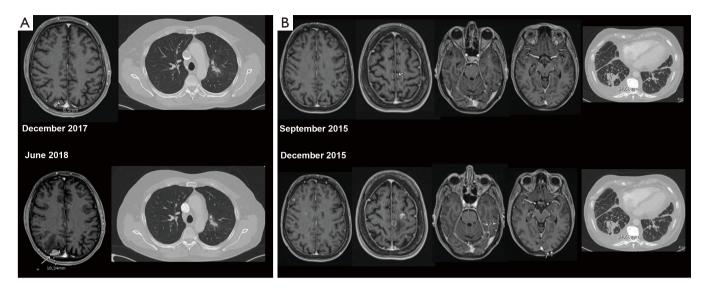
Exemplary cases with CNS-only progression and positive blood liquid biopsies. Two exemplary cases with brain-only progression and positive blood liquid biopsies. In patient A, growth of an occipital metastasis from <1 to 1.8 cm with meningeal contact (images on the left) was associated with detectable ctDNA in the blood (*BRAF* V600E with VAF 0.09%, and *KEAP1* R459Q with VAF 0.32%), while previous liquid biopsies of the same patient were negative. Extracranial tumor manifestations were stable (chest CT images on the right). In patient B, appearance of diffuse intracerebral lesions and multifocal meningeal carcinomatosis in December 2015 (partly depicted in the lower images, meningeal carcinomatosis shown with arrows) was associated with emergence of *ALK* F1174L (VAF 0.88%), and *ALK* G1269A (VAF 0.18%) mutations not detectable in the previous sample of September 2015 (upper images). Extracranial disease was stable.
